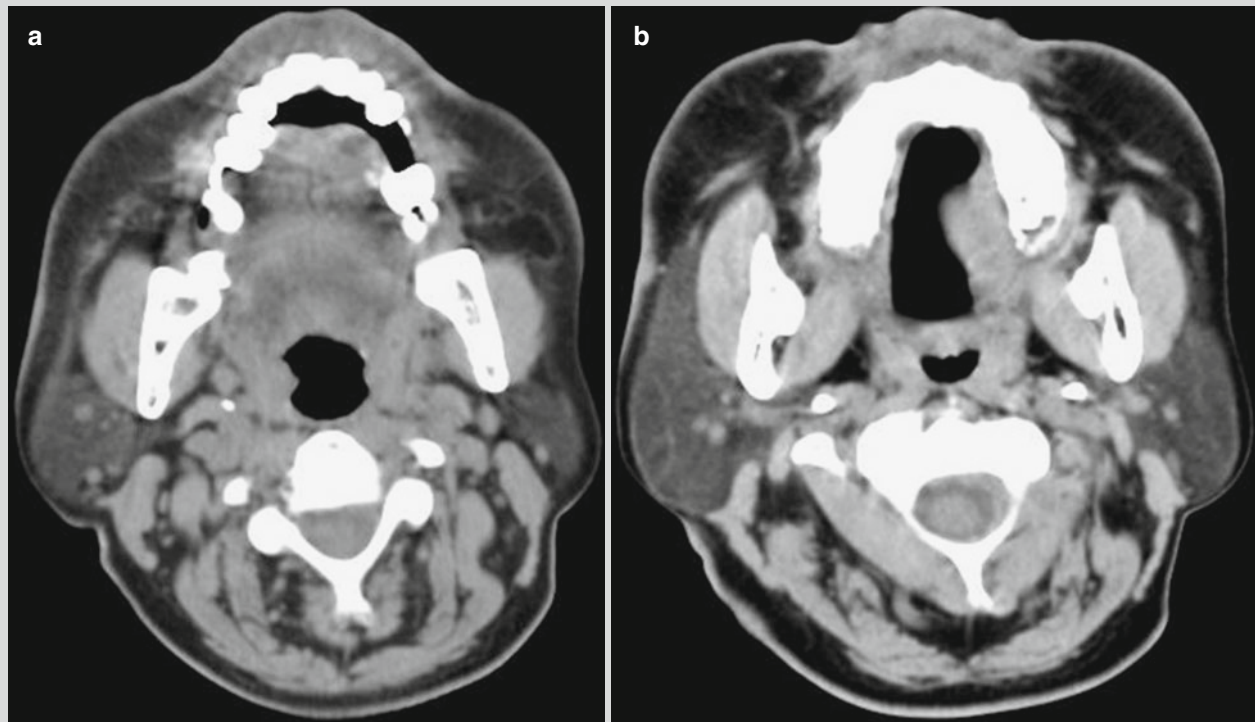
Facial changes of the patient with borderline lepromatous leprosy. (a, b) Cervical CT scan demonstrates multiple irregular lesions with low-density and clearly defined boundaries
